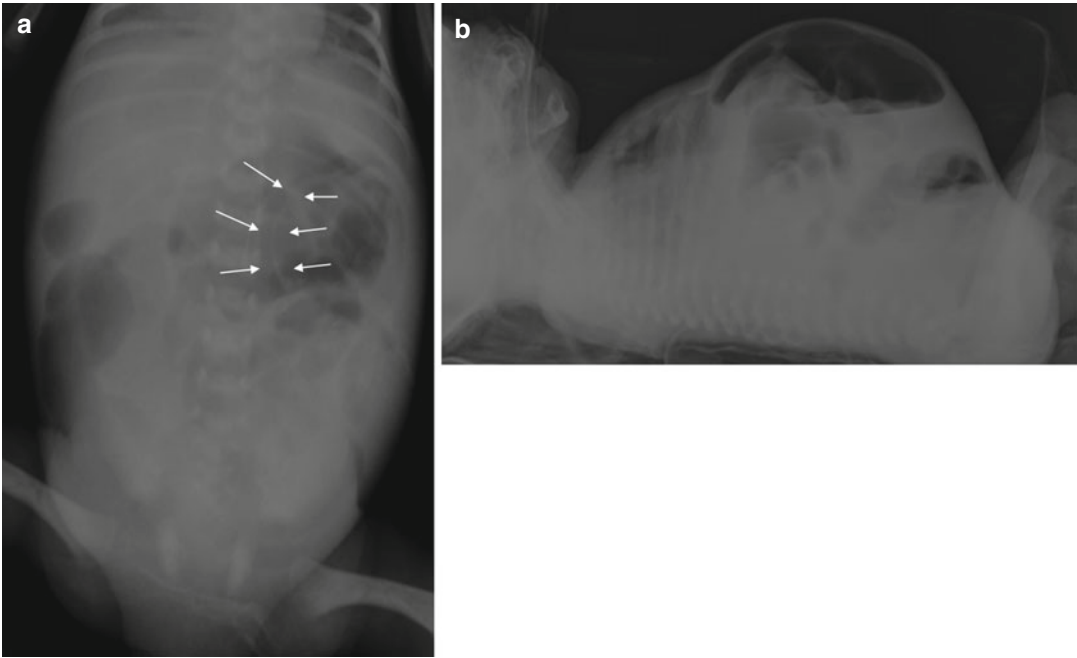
Abdominal supine and latero-lateral plain films in newborn with NEC (a–b): massive pneumoperitoneum. In this picture on supine film (a) it is possible to visualize
